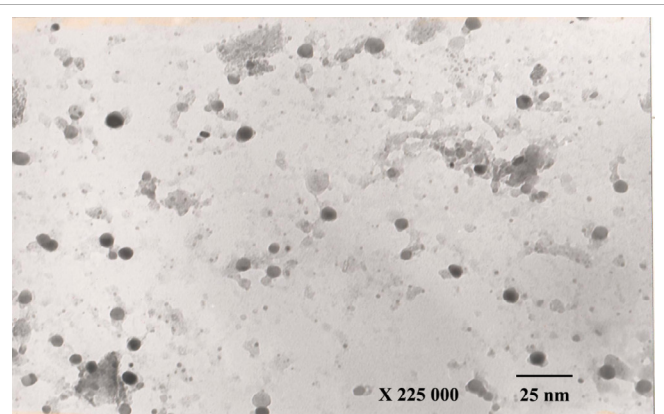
SeNPs after Ultrasonic Irradiation. TEM (JOEL JEM-100SX).
